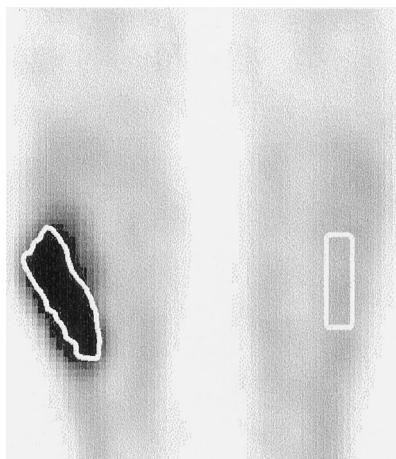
Coronal SPECT slice through the lower legs and knees of patient 4 with a low-grade myxoid liposarcoma showing a ROI through the tumor drawn at 80% of the maximum count value in the tumor and a contralateral background region.
